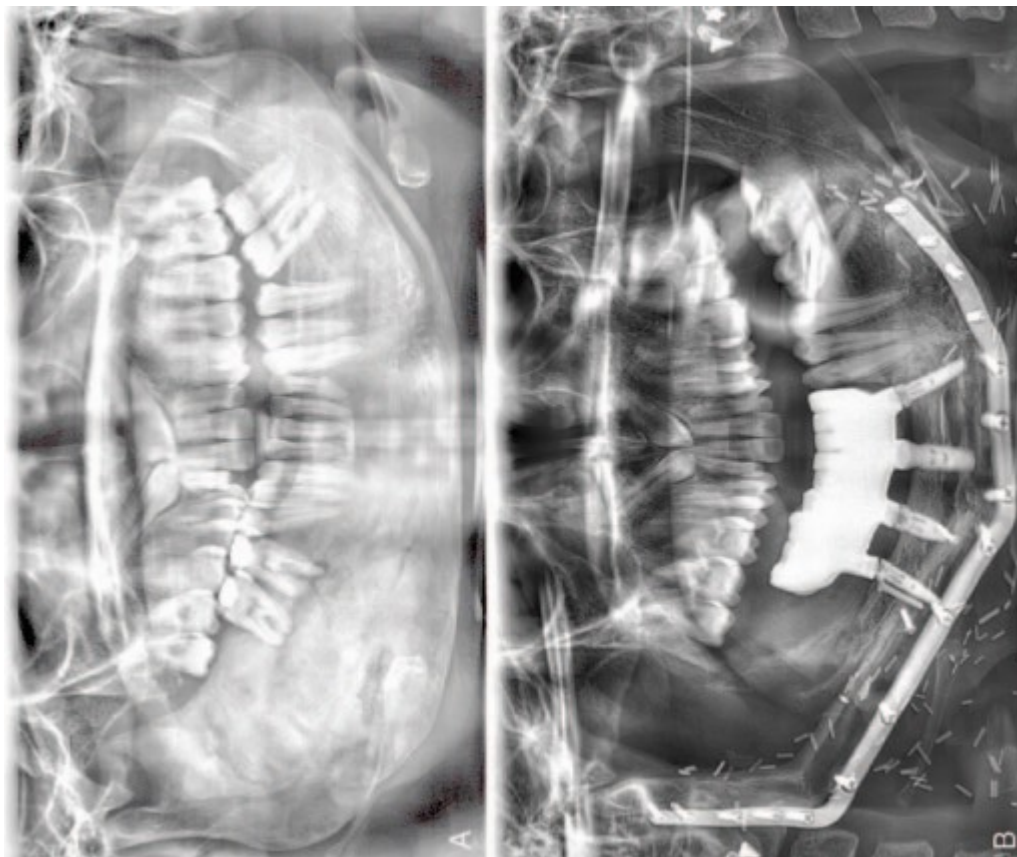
(A) Panoramic radiograph before surgery. (B) Phase II dental implant placement.
